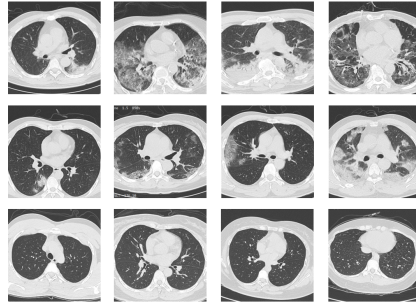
The images in chest CT sequence of different pneumonia patients. The three rows show the lung images of bacterial, viral patient and healthy person from top to bottom, respectively.
